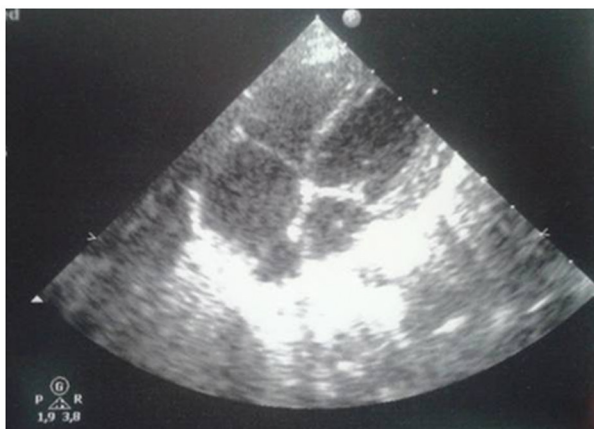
Echocardiogram showing (A) cardiac thrombosis (hyperdense image (30 mm × 4 mm) with tricuspid valve attached to both the atrial and ventricular faces) and (B) resolution after heparin treatment.
